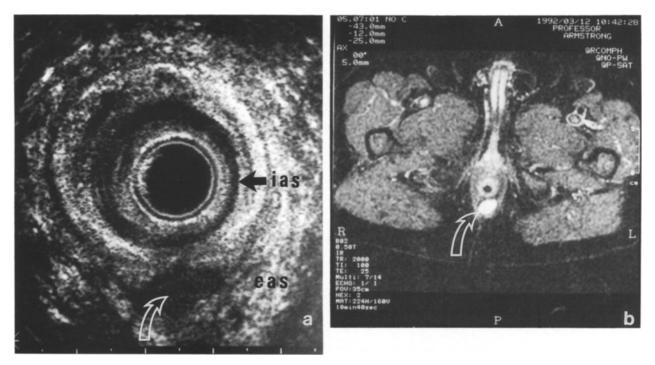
Anal endosonograph (a) and an axial MRI STIR image (b) of the same patient, both revealing a posterior intersphincteric abscess (open arrow) within an intersphincteric primary tract. ias = internal anal sphincter; eas = external anal sphincter.
